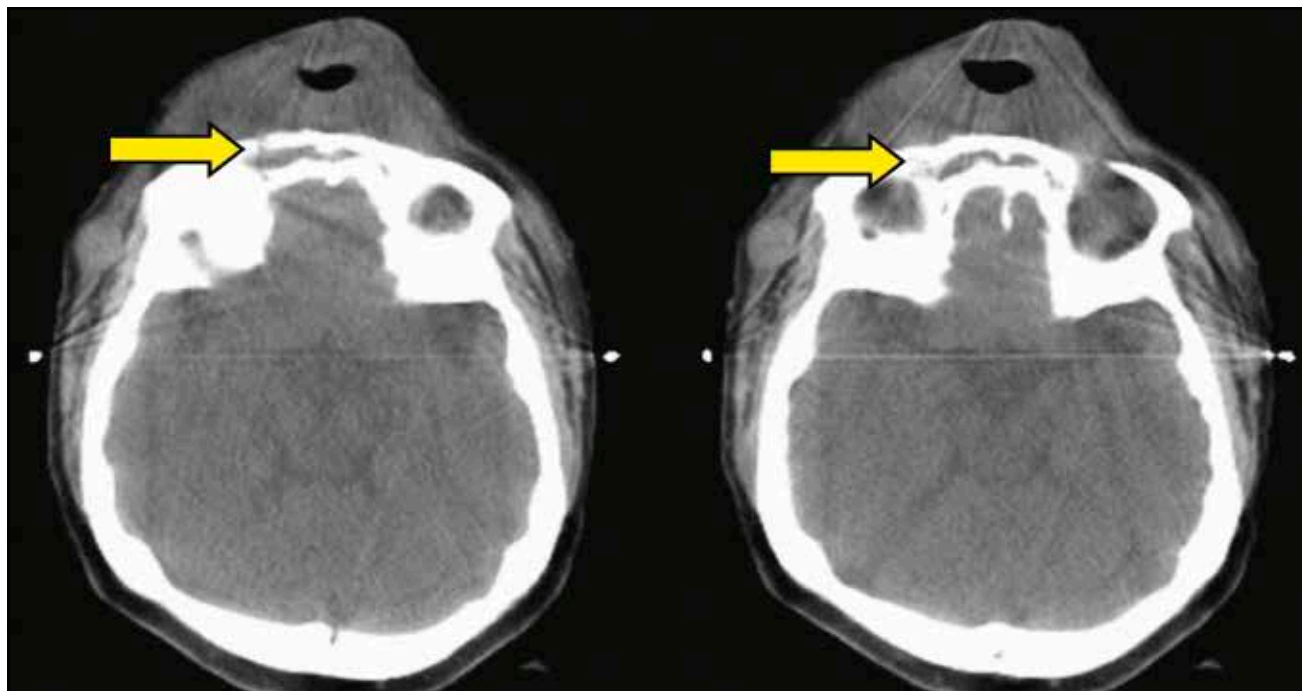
Cranio-facial CT scan without contrast showing erosion in the right frontal sinus.
